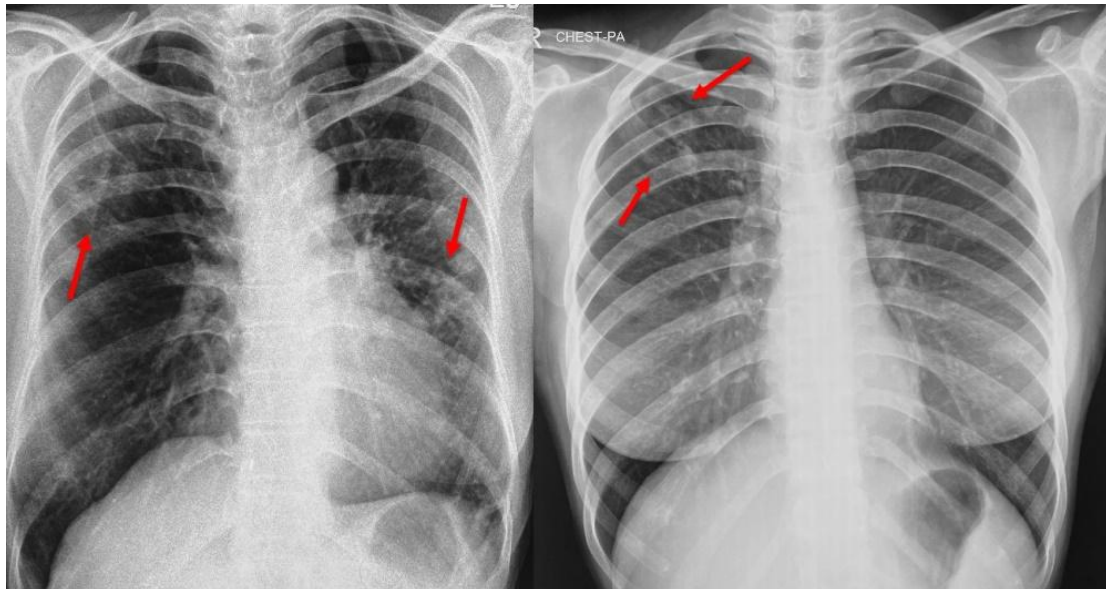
Chest X-ray for tuberculosis patients
